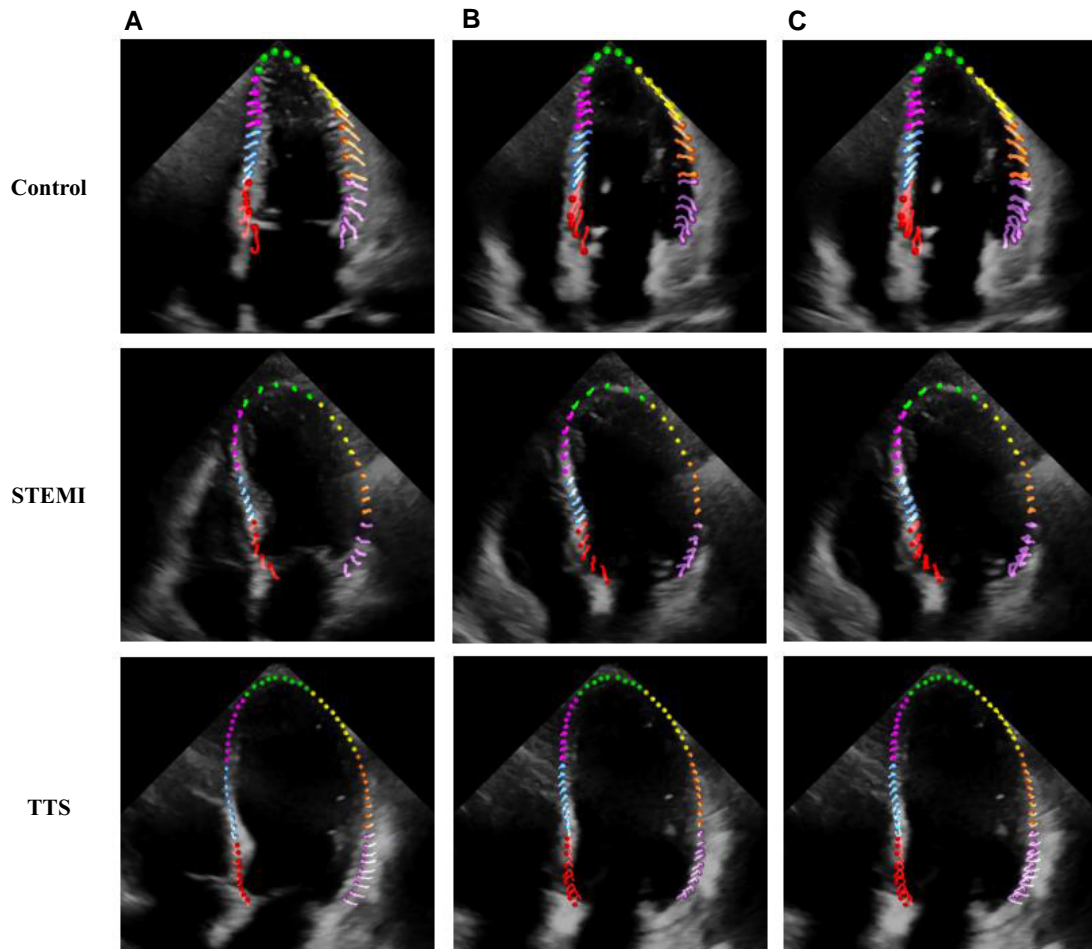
Myocardial optical flow assessment in control, STEMI, and TTS patients. Red, blue, magenta, green, yellow, orange, and purple pixels mark the basal-inferoseptum, mid-inferoseptum, apical-inferoseptum, apex, apical-anterolateral, mid-anterolateral, and basal-anterolateral sections, respectively, of an apical four-chamber view in an echocardiogram. (A) Motion trajectory for a systolic cycle. The lines corresponding to each colour mark the motion trajectory for each pixel. (B) Motion trajectory for a diastolic cycle. (C) Motion trajectory for a full cardiac (systolic + diastolic) cycle. STEMI, ST-segment elevation myocardial infarction; TTS, Takotsubo syndrome.
